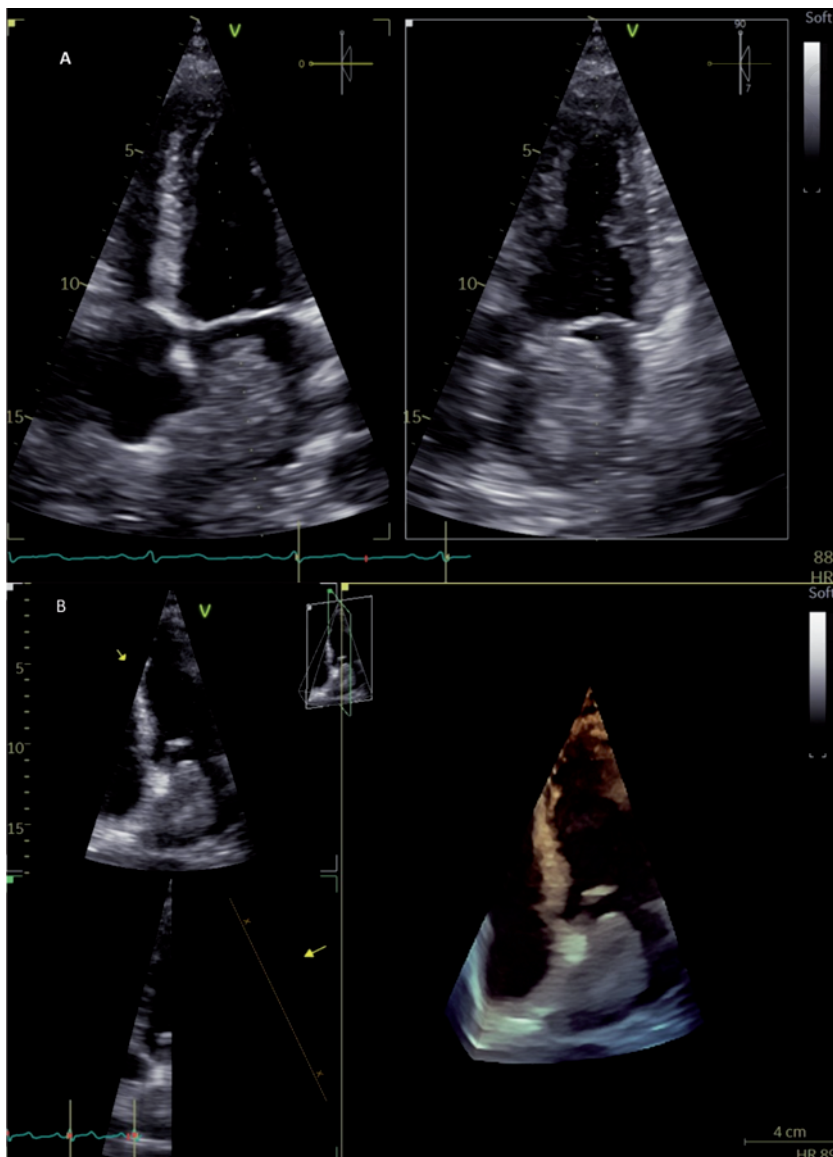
A) 2D transthoracic echocardiography; apical 4 chambers (left) and 2 chambers (right). B) 3D transthoracic echocardiography; mass occupying the left atrium.
